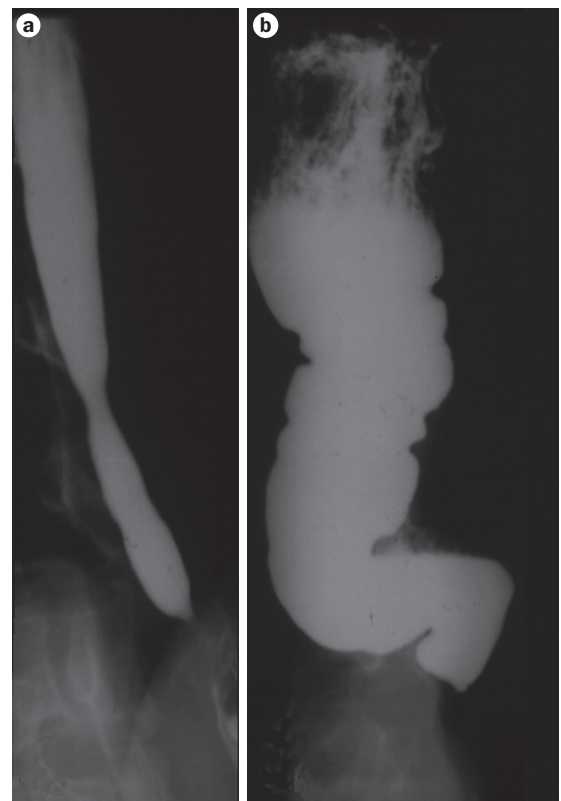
Radiographic images of two patients with achalasia after a barium swallow. a | Early achalasia. b | Advanced achalasia with megaesophagus.
